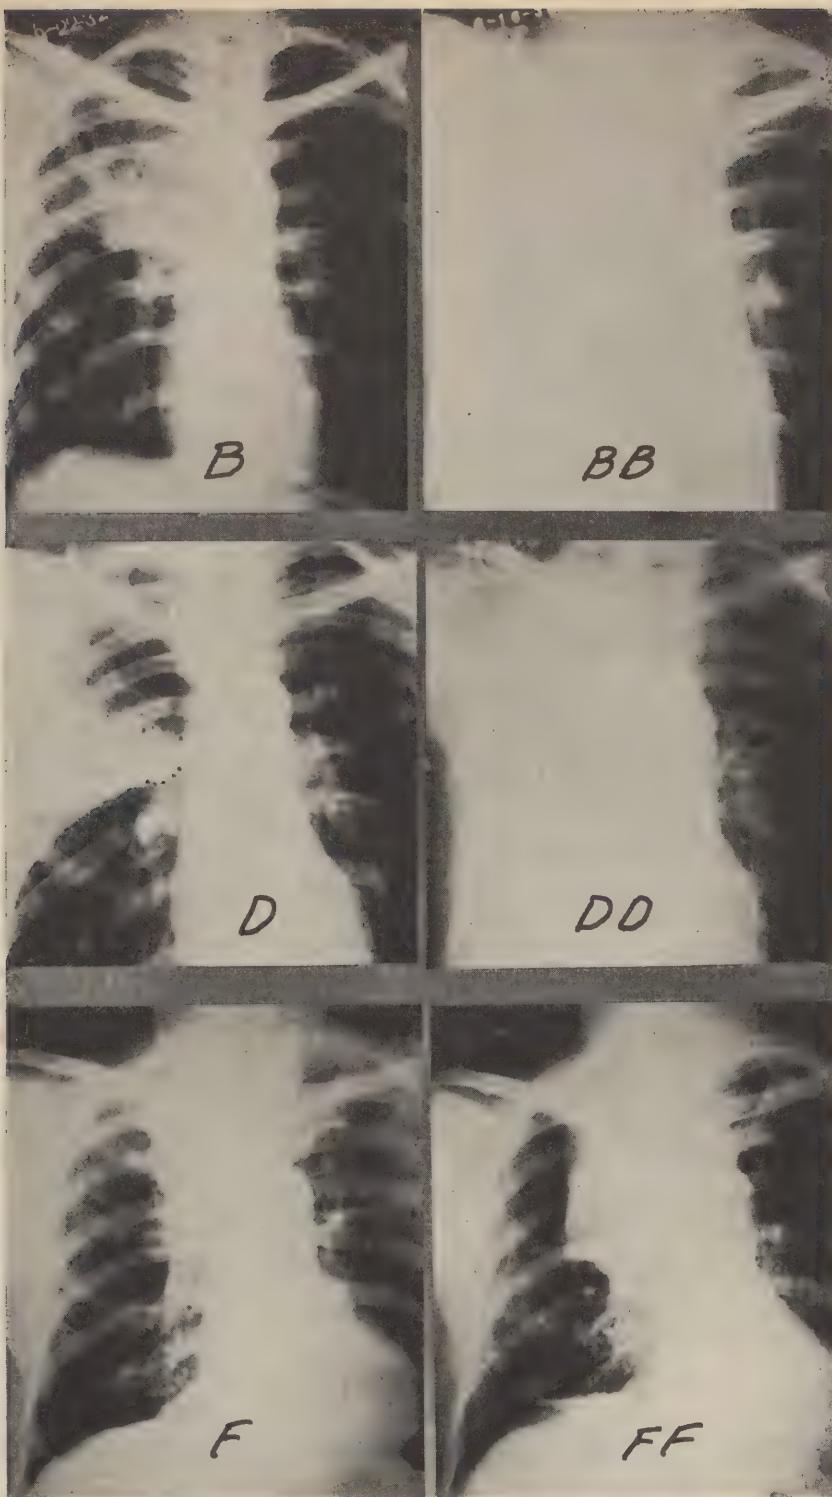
Examples of early symptomatology. *A*, This patient had visited the dispensary and complained of cough and chest pain for one month. Radiograph *A* was taken, and no follow-up was made until admission three years and four months later (*AA*). During this time pain, cough, hemoptysis, and weight loss had been progressive. *AA* was taken after aspiration of fluid and institution of air. Death occurred five months after admission. Autopsy showed adenocarcinoma.
